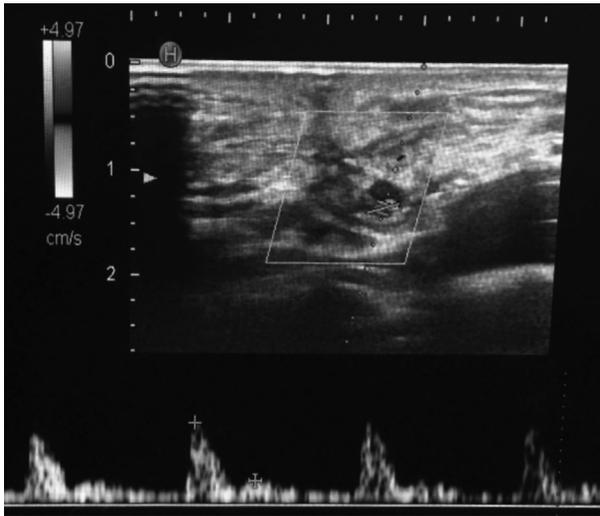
Six months later, control color doppler ultrasonography not detected blood flow in venous vessel.
